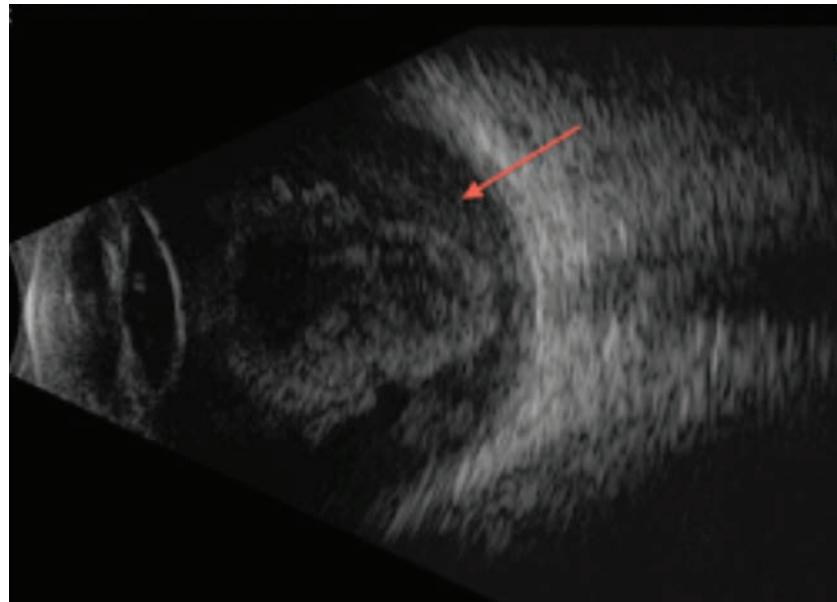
The retina, which is derived from the neuroectoderm, can be imaged using ultrasound, such as this B-scan of a retinal detachment.
